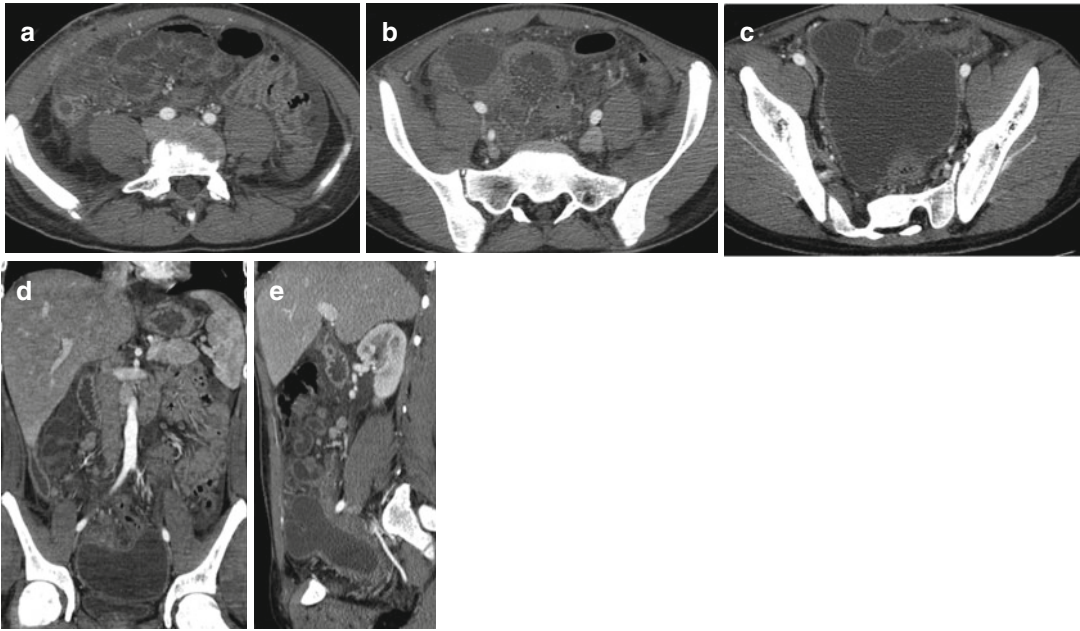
(a–c) CT, axial scans and (d–e) coronal and sagittal reconstructions show a fluid-filled appendicitis, with thickened wall and periappendiceal inflammatory changes. CT demonstrates the real extent of periappendiceal inflammation and the presence of periappendiceal abscess
